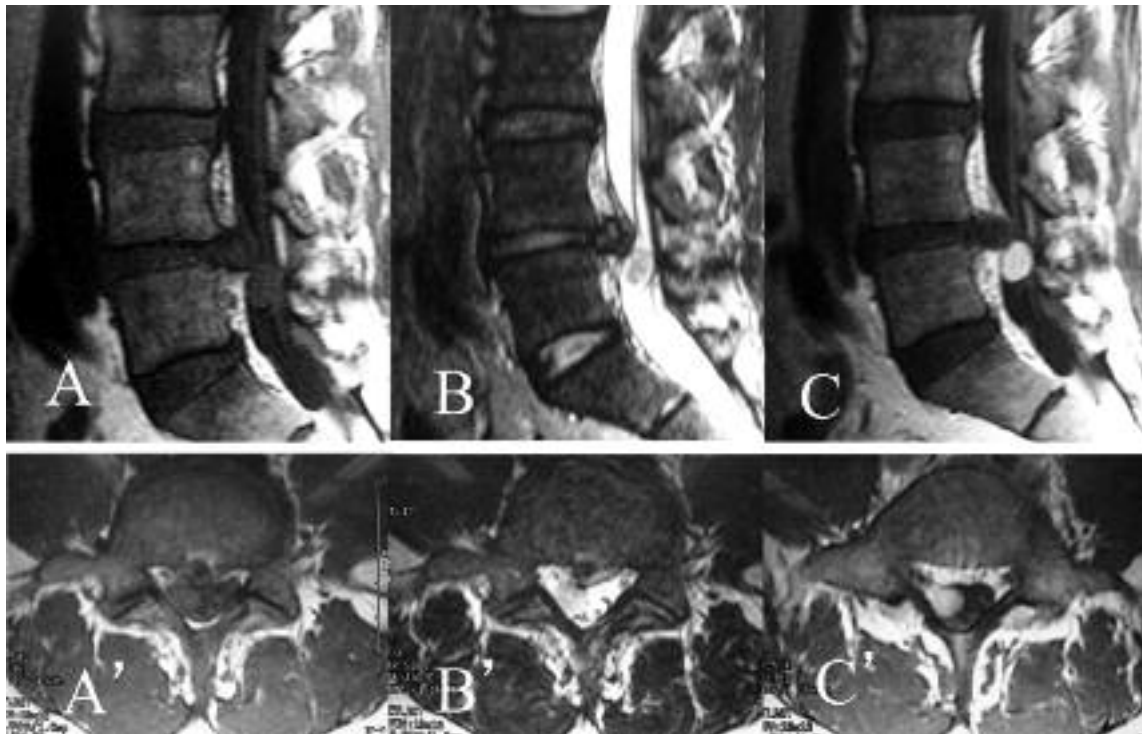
Left column : T1-weighted images, middle column : T2-weighted images, right column : Gd-enhanced images. A mass isointense on T1-weighted images and slightly hyperintense on T2-weighted images is observed in combination with L4/5 disc prolapse. The mass is homogeneously enhanced on Gd-MRI and does not appear to be connected to the disc prolapse shadow.
